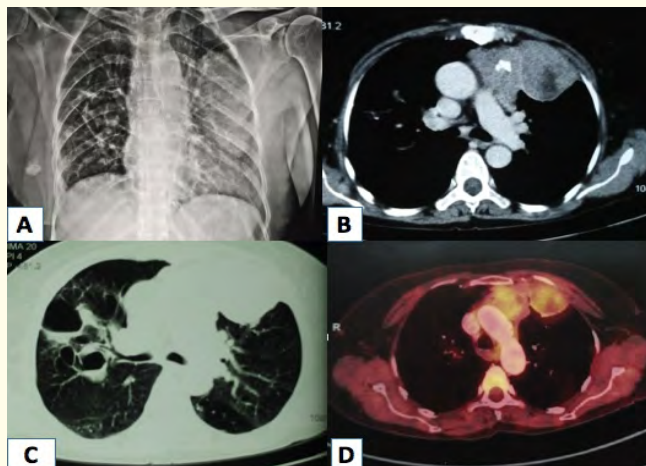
A) X-ray chest showing a mass lesion in left lung field. B and C) Ct chest revealed a mass lesion in upper mediastinum abutting the chest wall with multiple cystic bronchiectatic lesions in bilateral lungs fields. D) PET-CT showing heterogeneously enhancing, marginated, lobulated, solid-cystic mass in anterior mediastinum extending into left hemithorax.
